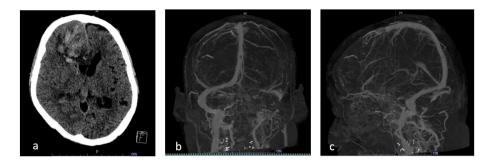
Computed tomography imaging and venogram findings of case 2
